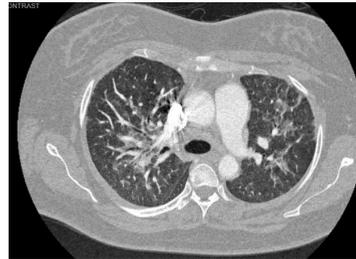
Initial CT chest with contrast.
